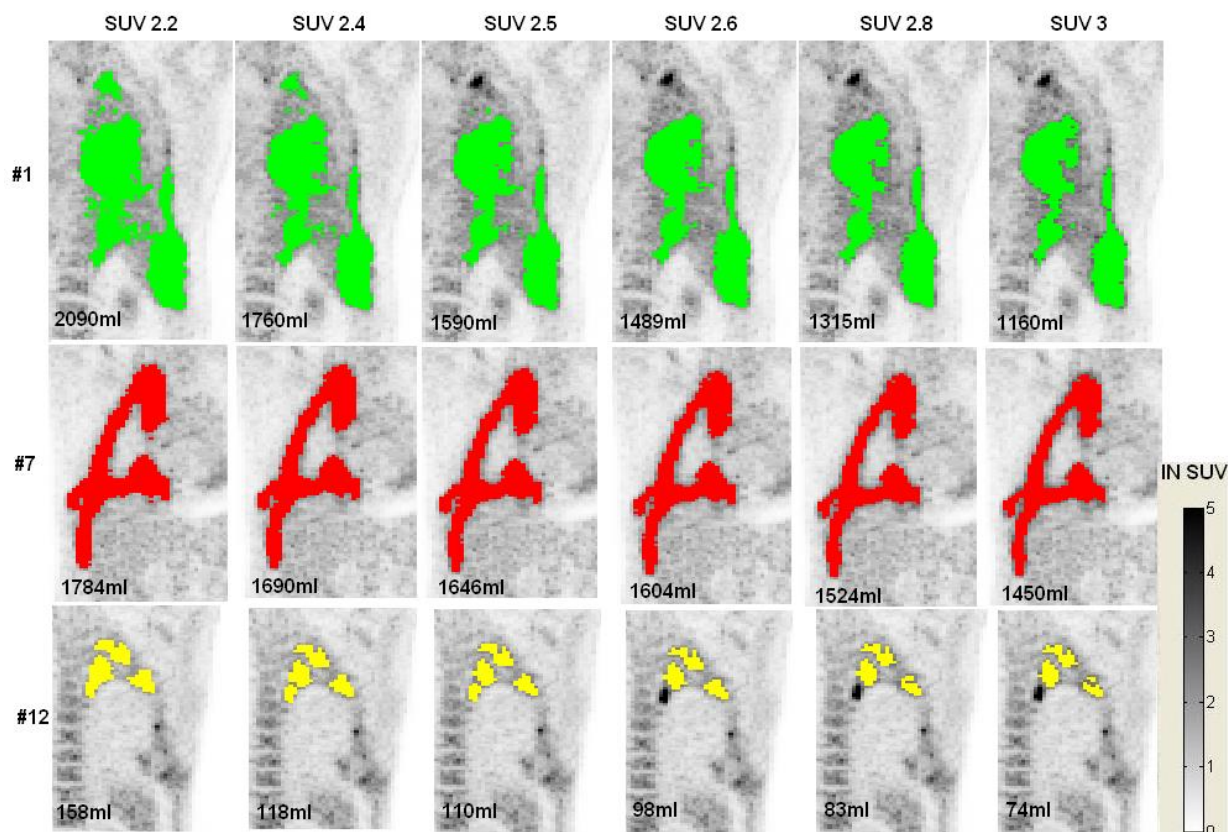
Segmentation using Different Fixed SUV Thresholds
